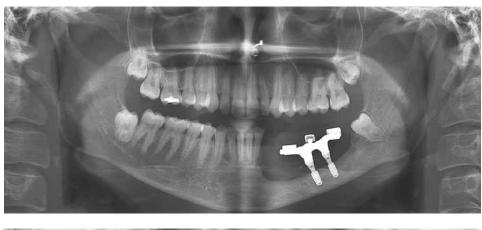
Orthopantomograph showing implants with prosthesis.
